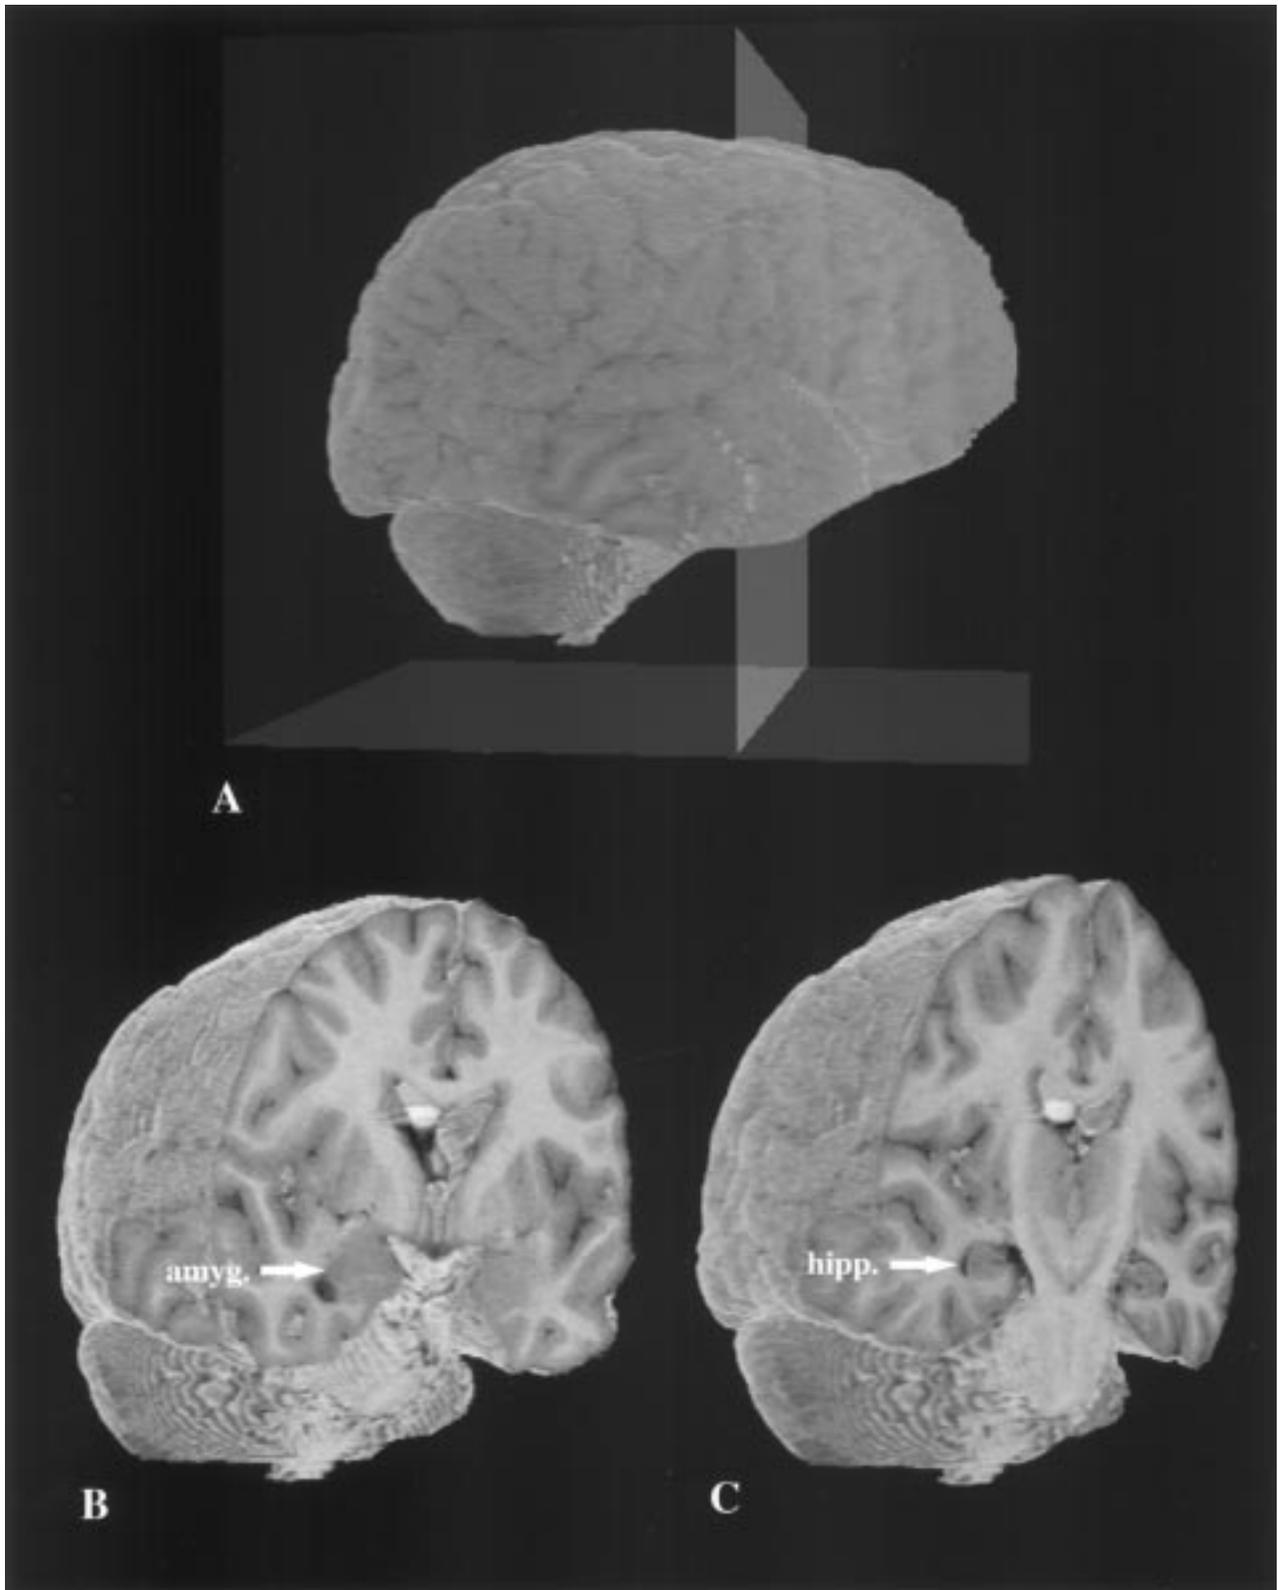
(Panel A) Three-dimensional reconstructed image using *VirtualSurgery* program from a proton density-weighted MRI scan of the whole brain in Fig. 1. The transverse plane through the 3D image in Panel A represents the location of the virtual cut made through the amygdala displayed in Panel B. A second cut was made further caudal through the hippocampus (Panel C).
